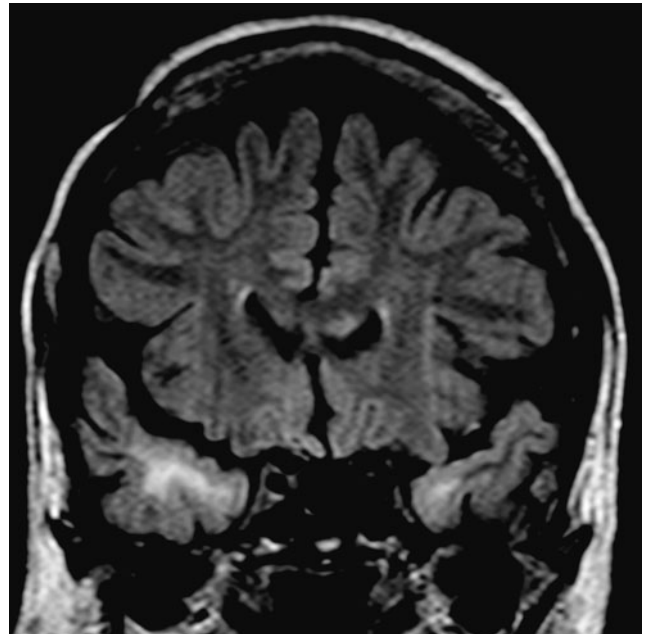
Magnetic resonance imaging fluid attenuation recovery coronal section demonstrating white matter hyperintensities in bilateral temporal lobes. The right side, which received the greatest amount of radiation, is significantly more affected than the left side.
